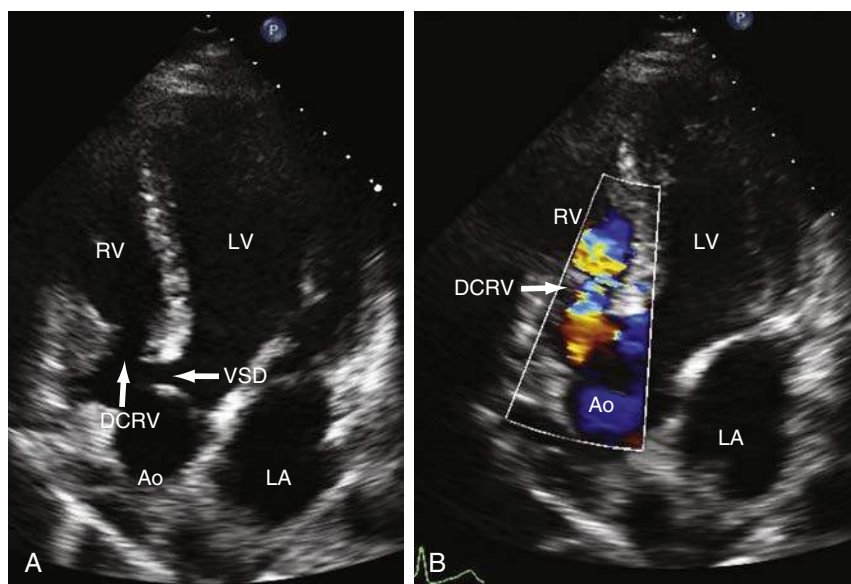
A, Two-dimensional transthoracic echocardiography (2D TTE) from apical five-chamber view showing a perimembranous VSD (horizontal white arrow) with DCRV (vertical white arrow). B, Color Doppler showing the flow acceleration from the high- to low-pressure chambers of the RV (white arrow). Ao, Aorta; DCRV, double-chamber right ventricle; LA, left atrium; LV, left ventricle; RV, right ventricle; VSD, ventricular septal defect.
